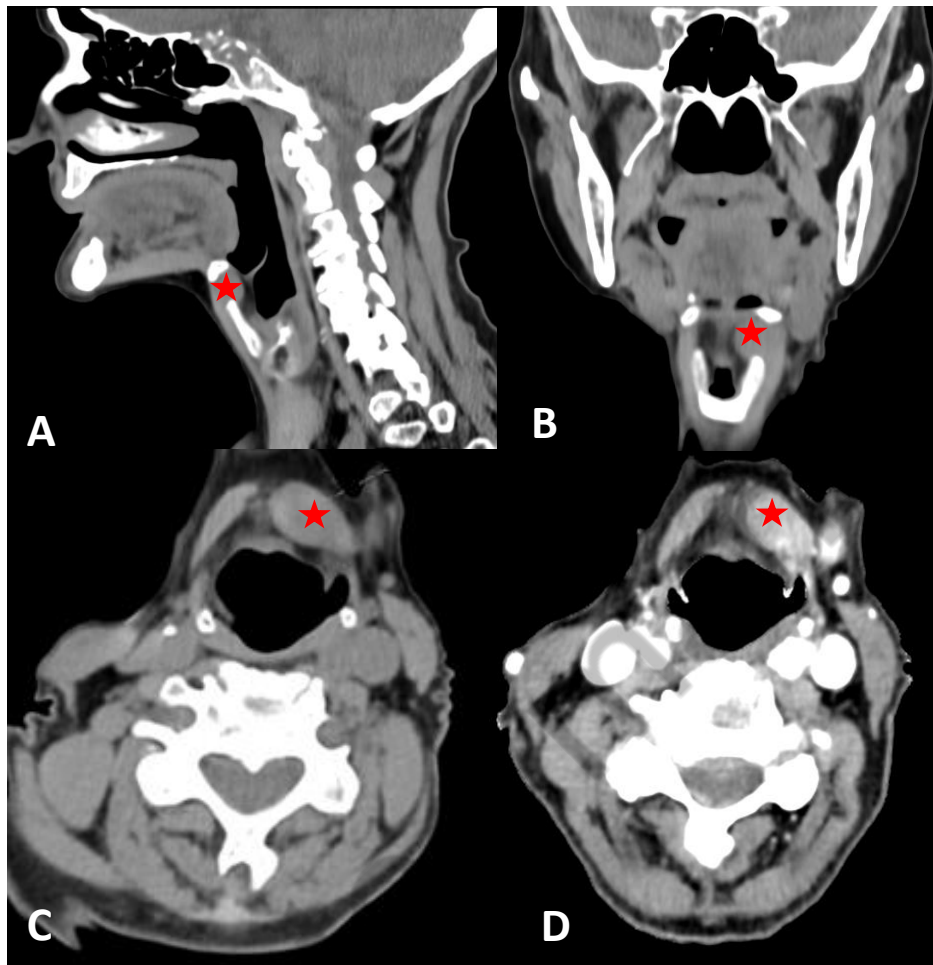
CT scan of the neck, sagittal (A), coronal (B) and axial (C) views show an ovoid lesion in the left thyroid membrane, located strictly in the submucosal layer, with slight deformation of the vallecula and contrast enhancement (D)
